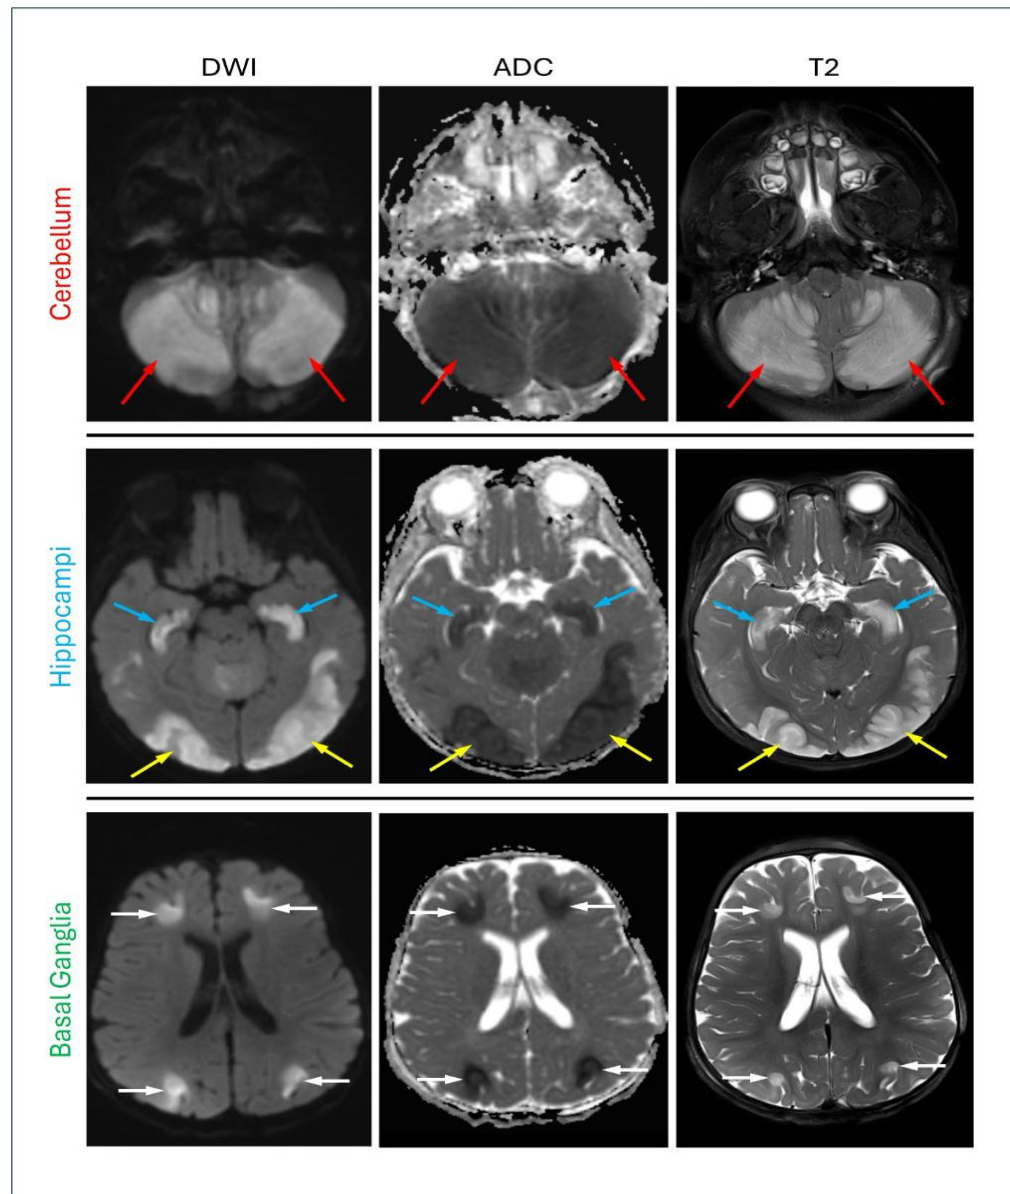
MRI case example of POUNCE syndrome in a 12-month-old female patient with representative DWI, ADC, and T2 axial images. Areas of restricted diffusion and T2 signal hyperintensity are demonstrated in the cerebellum (red arrows) and hippocampi (blue arrows). In addition, there are areas of similar signal abnormality involving the posterior cerebral cortex (yellow arrows) and bilateral cerebral white matter (white arrows).
